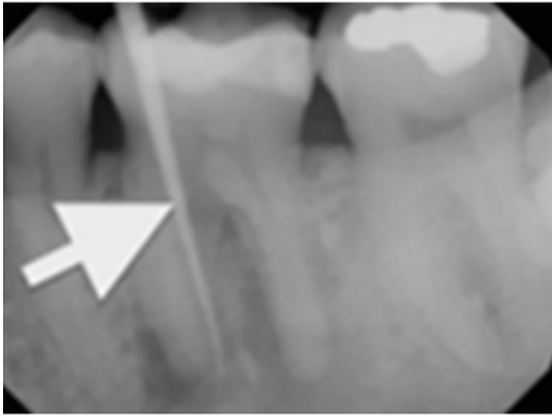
Radiographic confirmation of periapical diagnosis—chronic apical on tooth No. 19. Note the tracing of the inserted gutta-percha to the etiology.
